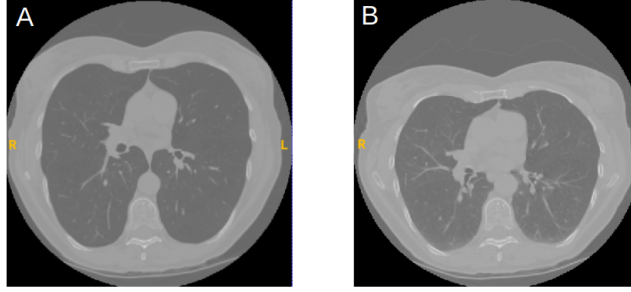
Inhale(A) and Exhale(B) CT image pair of COPD1
